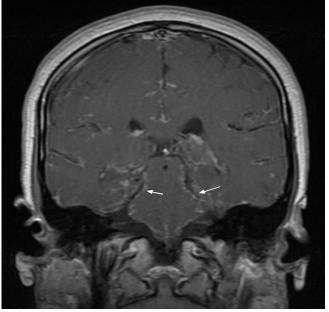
MRI brain with contrast showing lepto-meningeal thickening and nodularity (arrows).
